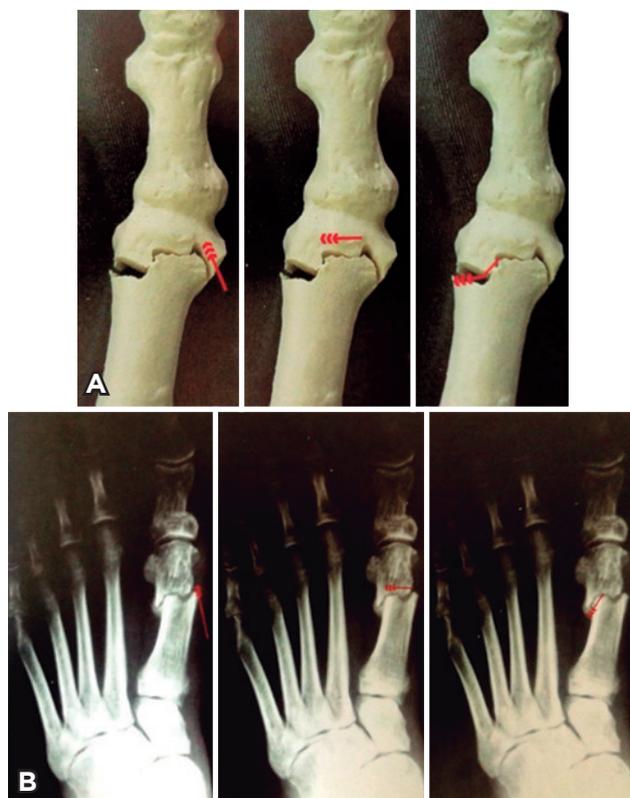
A. Sequence of M1 osteotomy planes in Sawbones. B. Same sequence demonstrated in radiographs.
